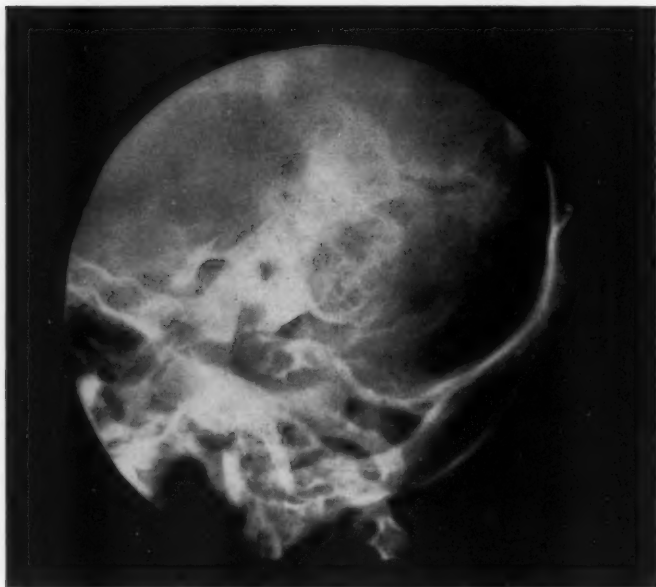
Roentgenogram, left mastoid, June 19, 1952.
